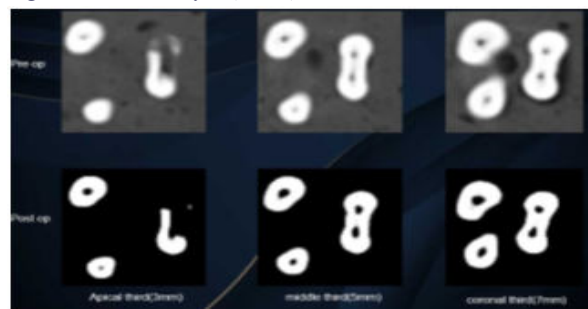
CBCT analysis (DIA X)
